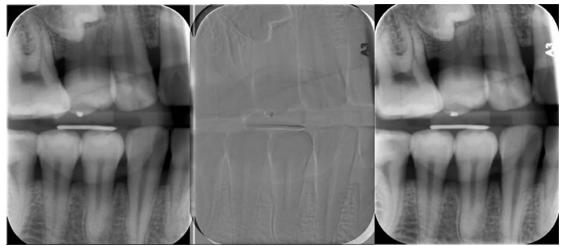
Subtraction radiograph with both vertical and horizontal deviations below 2 degrees: vertical deviation 1.43 degrees and horizontal 1.71 degrees.
